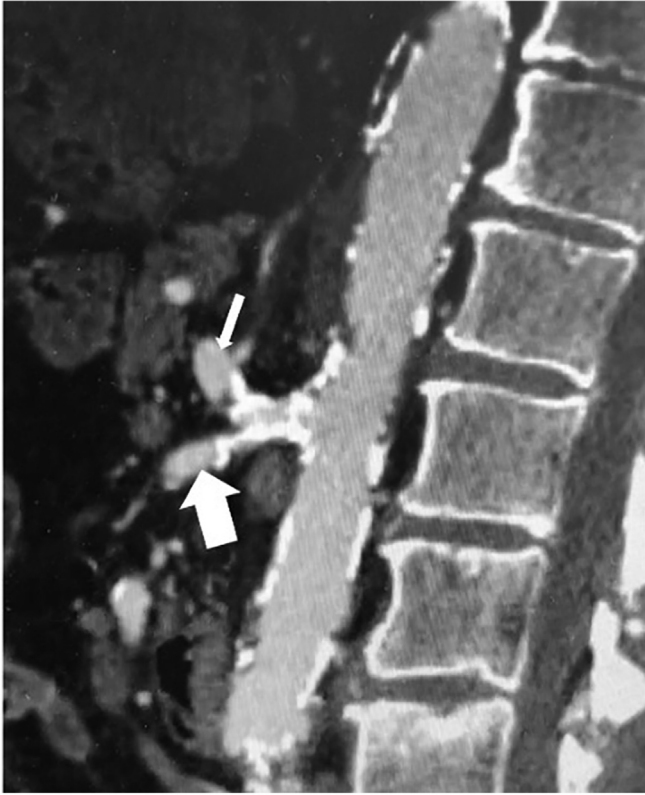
Sagittal reconstruction of computed tomography arteriogram demonstrating stenosis of the celiacomesenteric trunk (CMT) bifurcation (celiac axis [CA], thin arrow; superior mesenteric artery [SMA], thick arrow).
